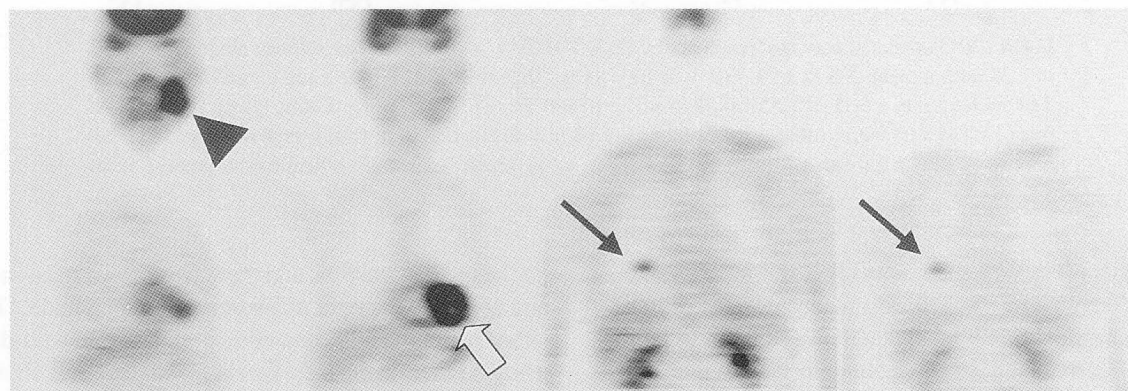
Case 25. FDG-PET showed the distant metastasis in right lower lung (arrows). High FDG accumulation of the primary tumor was observed in the left mandible (SUV = 10.67, T/B = 11.47) (arrow head). The physiological uptake of FDG was shown in the heart (open arrow).
